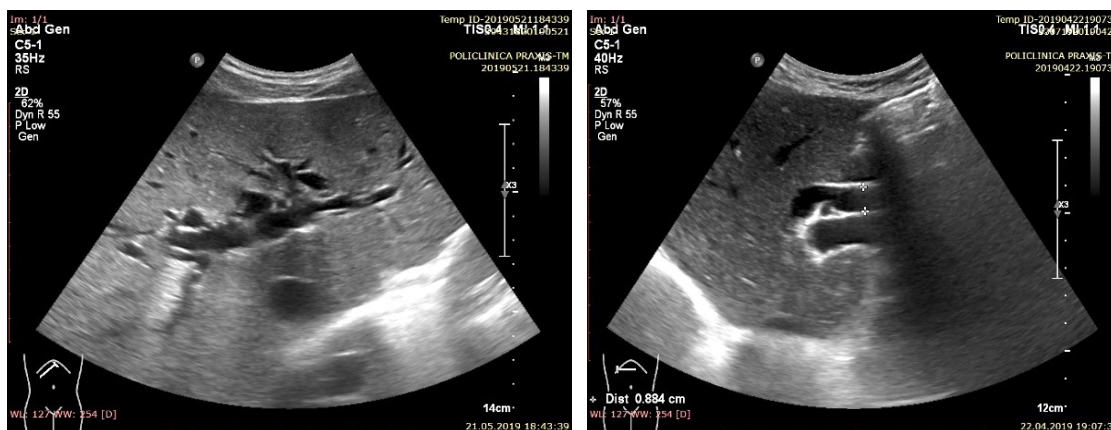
Ultrasound aspect of biliary obstruction: The "spider" aspect in the center of the liver (left), and Fig. 5.18. Enlarged main biliary duct (right)
